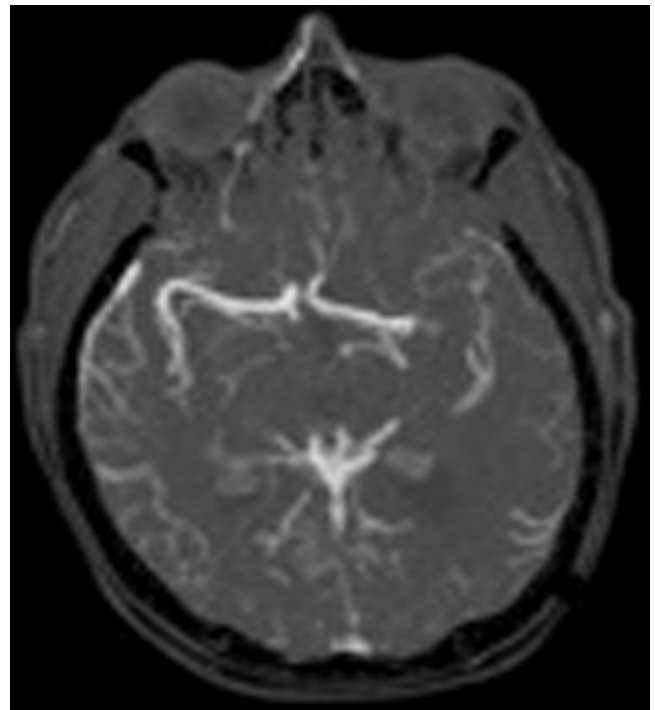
Axial CT angiogram with maximum intensity projection reveals a left MCA occlusion between the M₁ and M₂ segments.
